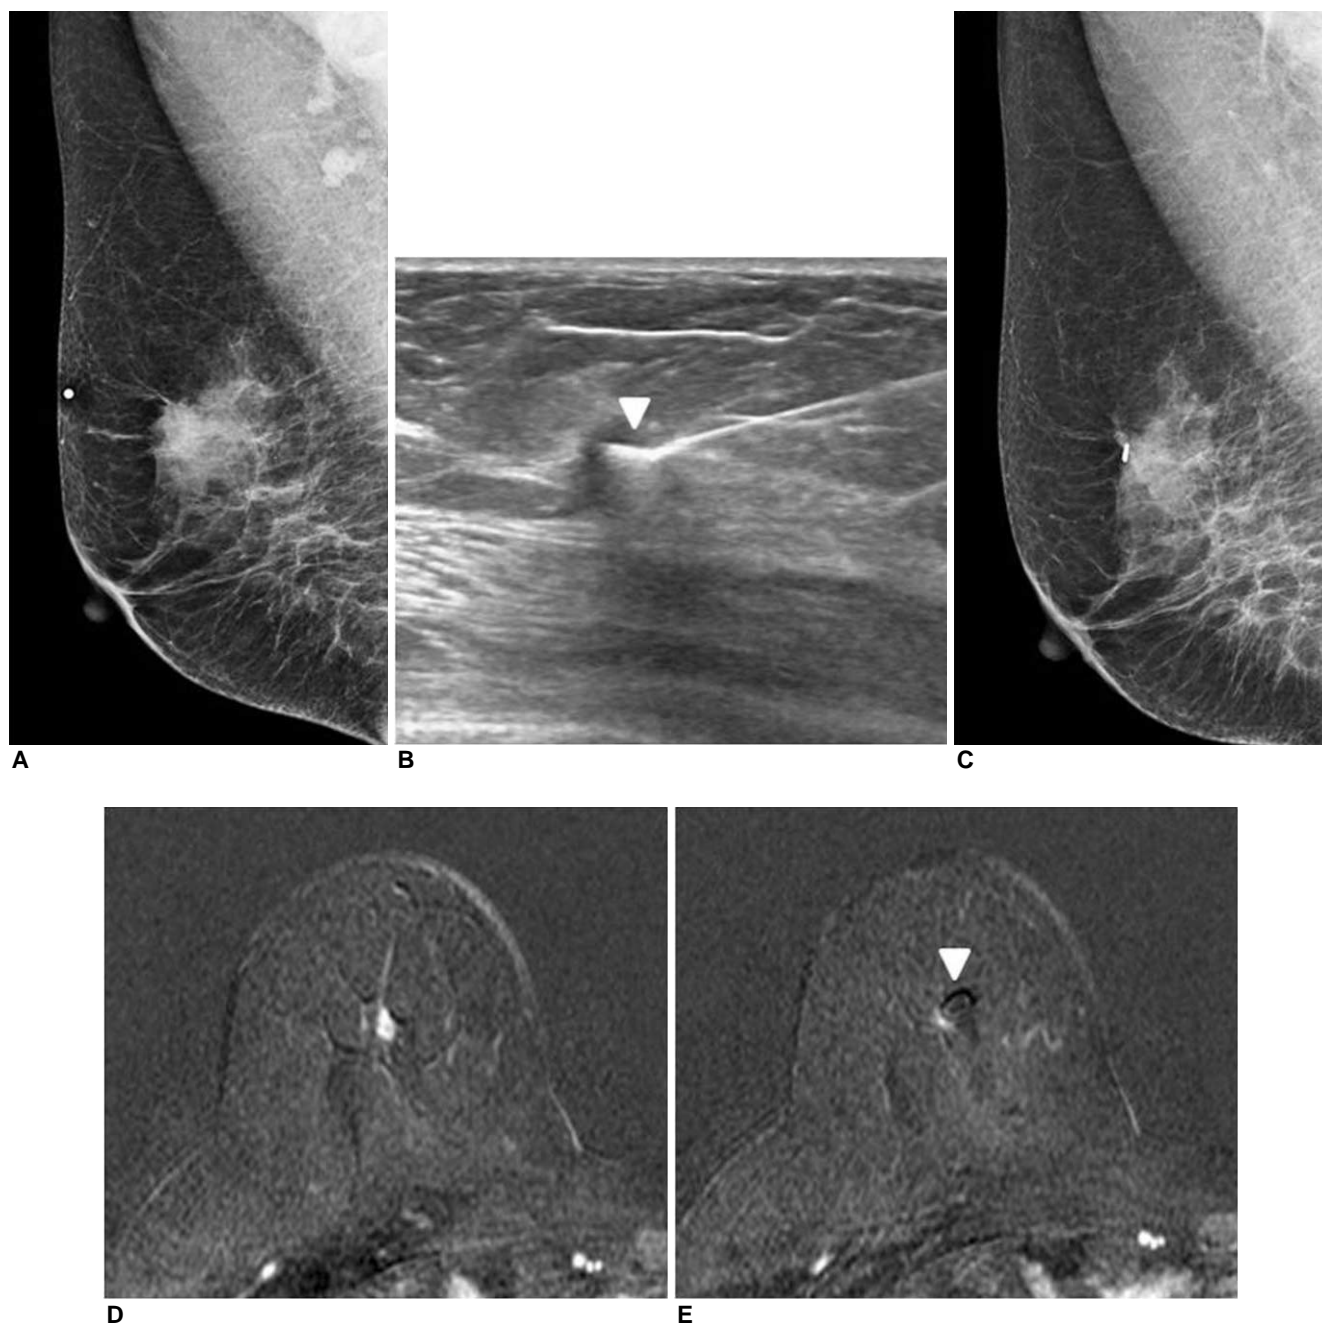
A 58-year-old female patient with a palpable right breast cancer that responded to neoadjuvant chemotherapy. Initial mediolateral oblique mammogram (A) shows approximately 2.5 cm focal asymmetry with internal microcalcifications corresponding to a palpable lesion, and multiple enlarged axillary lymph nodes. Ultrasonography (B) obtained during marker implantation shows a marker clip (Horizon ligating clip, arrowhead) that has been deposited at the tip of a 14-gauge needle at the periphery of the 1 cm irregular shaped hypoechoic mass that responded to four cycles of neoadjuvant chemotherapy. Mediolateral oblique mammogram after clip insertion (C) confirms the location of the implanted marker clip at the periphery of the residual tumor. Axial contrast-enhanced subtracted MR image of the right breast at completion of neoadjuvant chemotherapy shows a 0.7 cm enhancing residual mass (D) and a marker clip (E, arrowhead) at the periphery of the mass.
